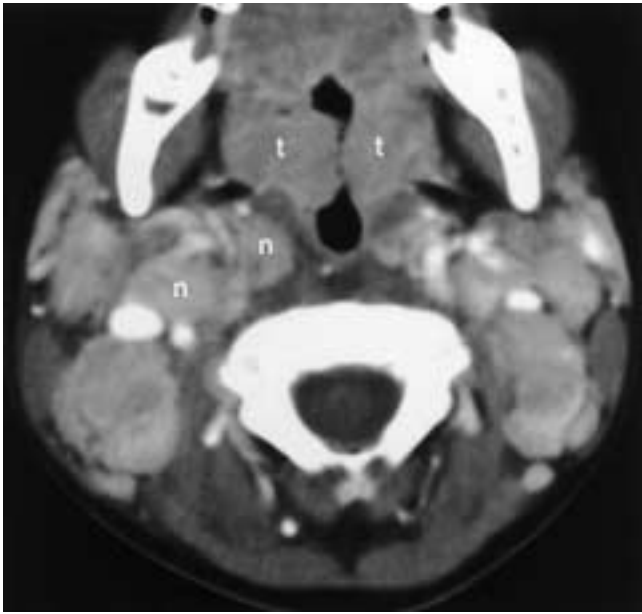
Streptococcal tonsillitis and lymphadenitis in a 4-year-old girl. Contrast-enhanced CT reveals marked enlargement and enhancement of the palatine tonsils (*t*) and lymph nodes (*n*) with narrowing of the airway. There is posterolateral displacement of the carotid sheath.
